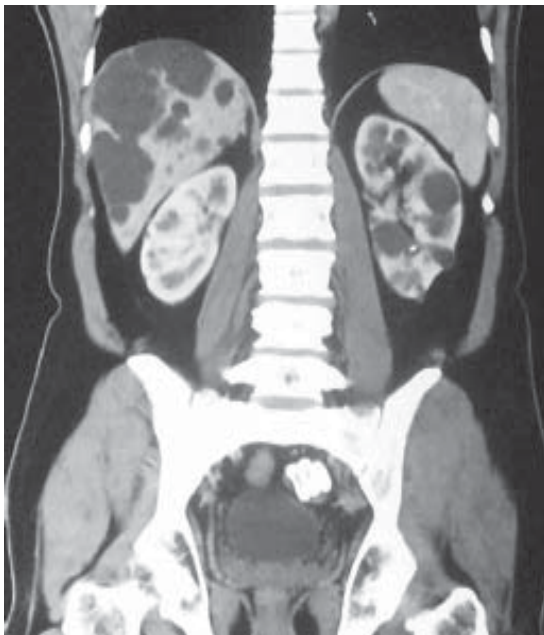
CT Scan showing calculi near bladder
